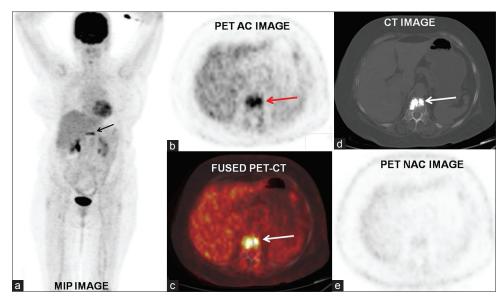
[18F] fluoro-2-deoxy-d-glucose positron emission tomography/computed tomography (F-18 FDG PET/CT) scan. (a) The maximum intensity projection (MIP) image. (b) Attenuation corrected PET only image and (c) Fused PET-CT images- reveal increased tracer uptake in D10 vertebra. (d) Corresponding CT images showed presence of bone cement used for strengthening the vertebra. (e) The NAC image did not reveal abnormal FDG uptake in the D10 vertebra
